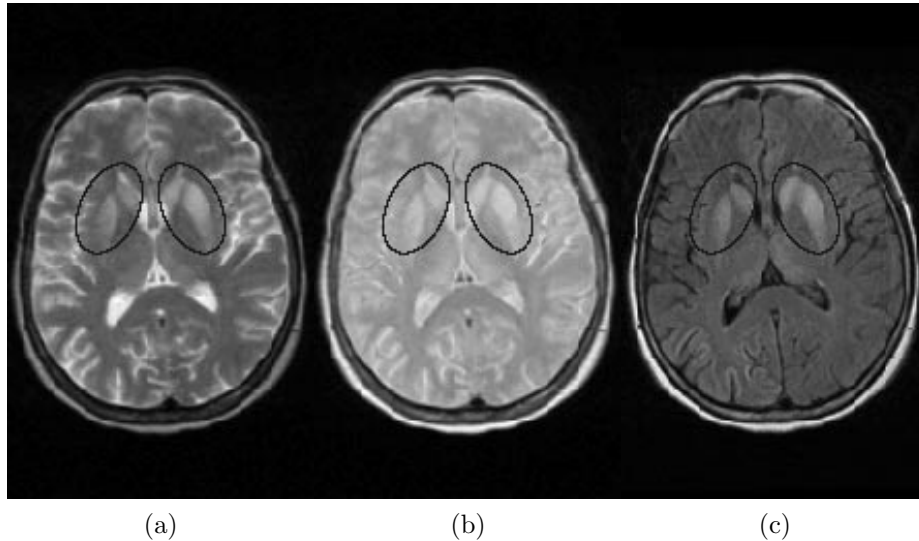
Example MR brain scan of a patient suffering from sporadic CJD: T2-weighted (a), PD-weighted (b), and FLAIR image (c). Signal abnormalities in the deep gray matter structures are encircled.
